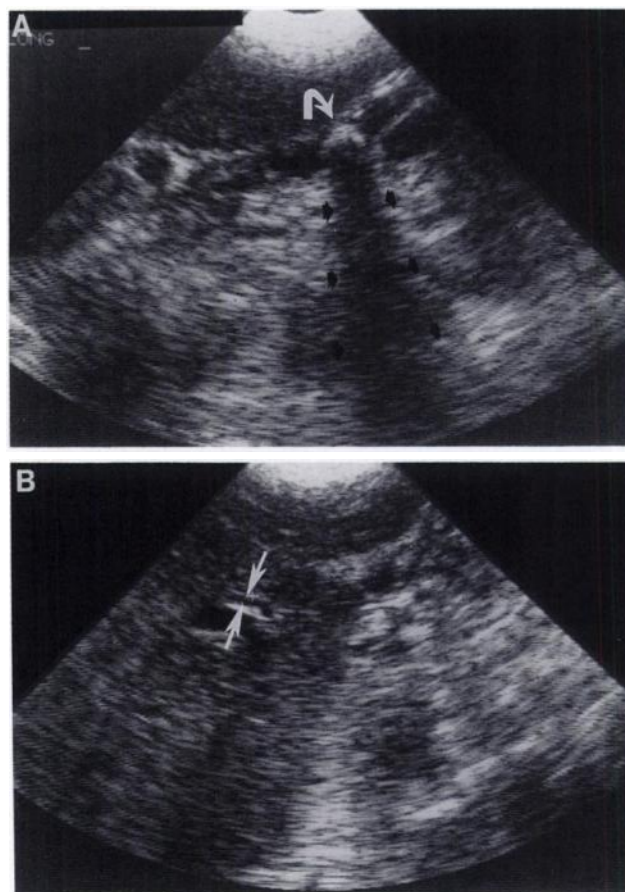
An ultrasound performed several days following ERCP. (A) An echogenic structure (curved arrow) in the gallbladder with shadowing is consistent with a gallstone. (B) The common bile duct (arrows) which measures 4 mm is a significant change from the image in Figure 2B performed before ERCP, and indicates that the common bile duct is no longer obstructed.
